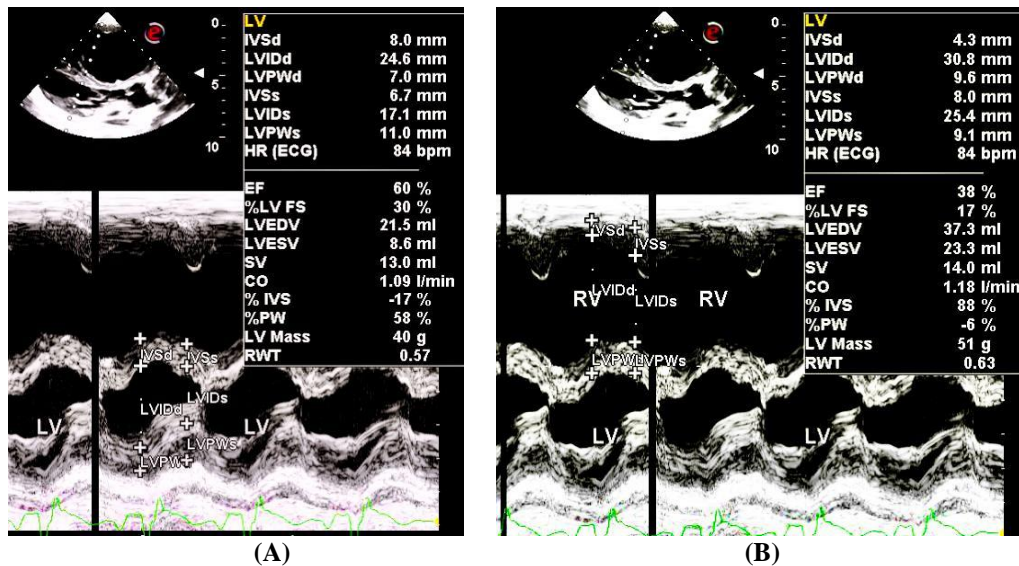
M-mode echocardiographic measurements. (A) M-mode measurements of LV; (B) M-mode measurements of RV.
